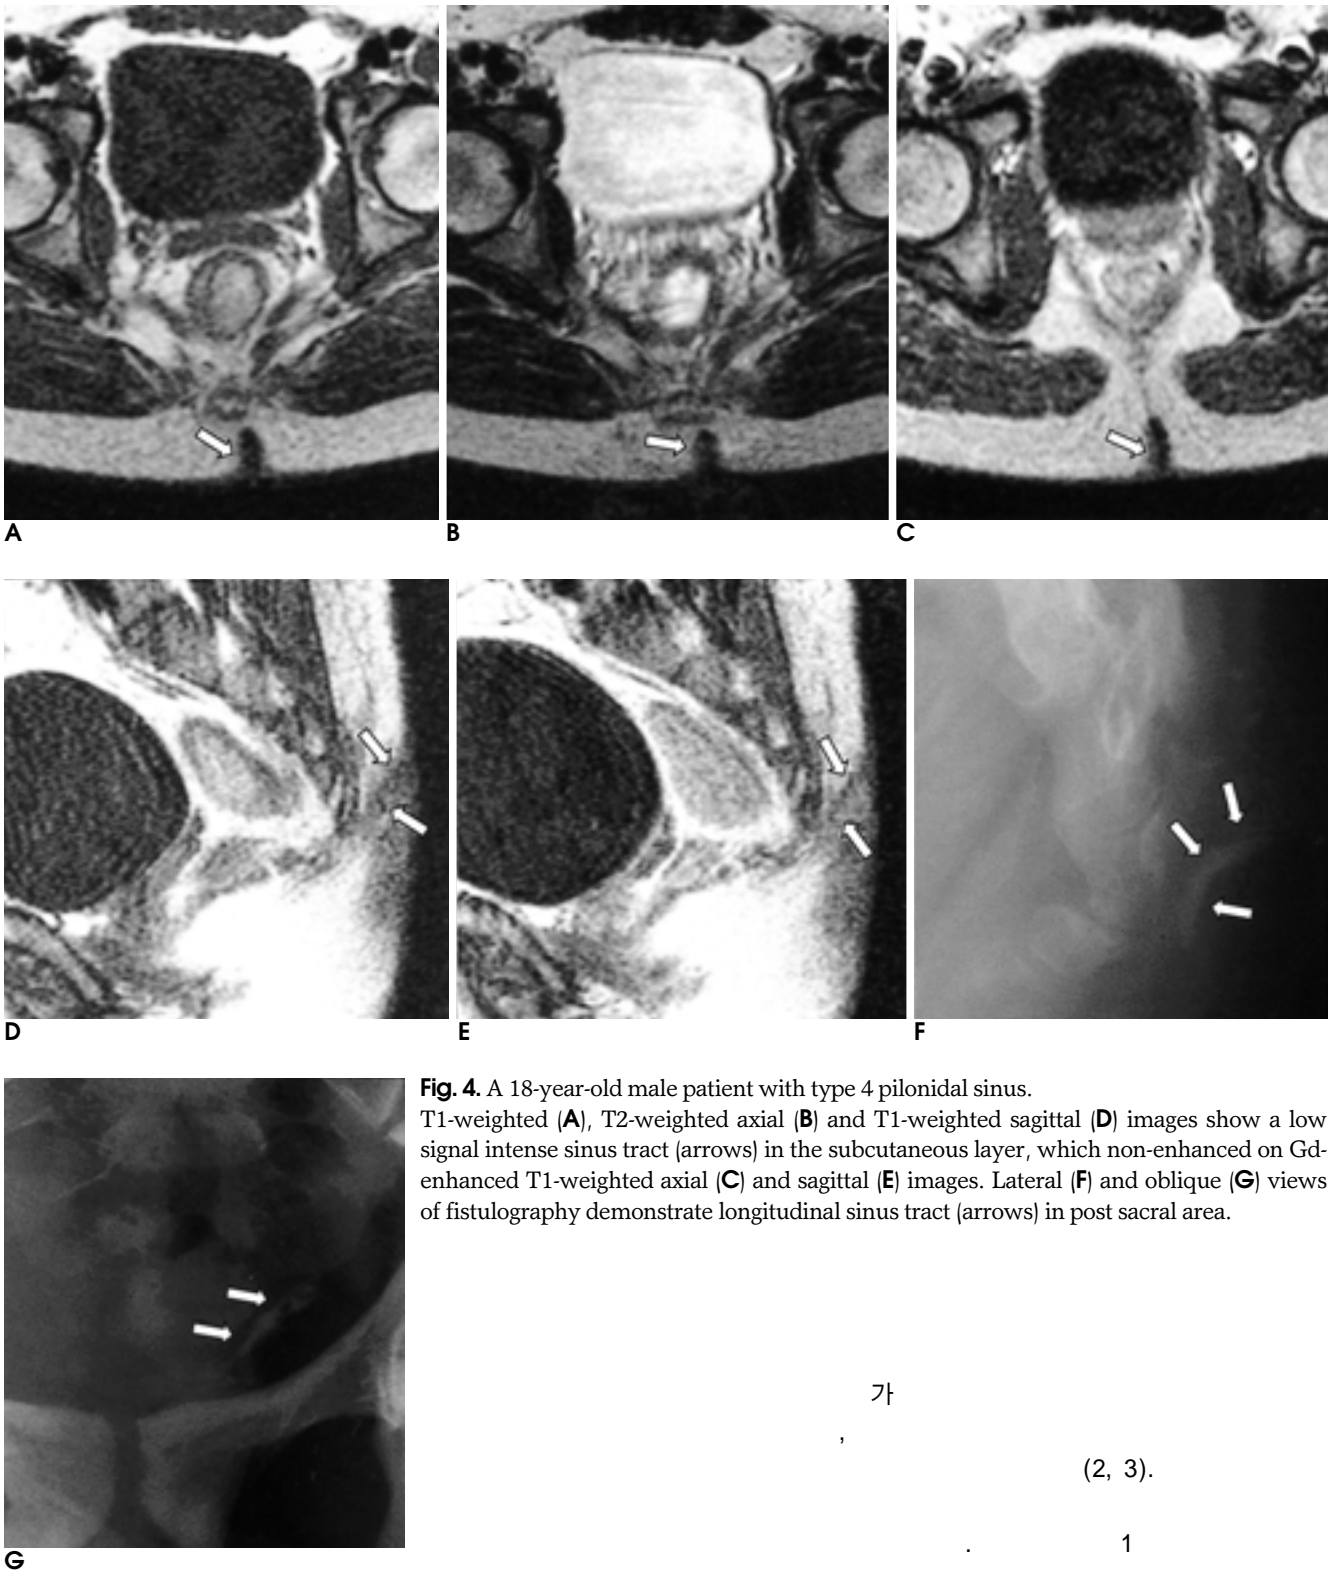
A 18-year-old male patient with type 4 pilonidal sinus. T1-weighted (A), T2-weighted axial (B) and T1-weighted sagittal (D) images show a low signal intense sinus tract (arrows) in the subcutaneous layer, which non-enhanced on Gd-enhanced T1-weighted axial (C) and sagittal (E) images. Lateral (F) and oblique (G) views of fistulography demonstrate longitudinal sinus tract (arrows) in post sacral area.
